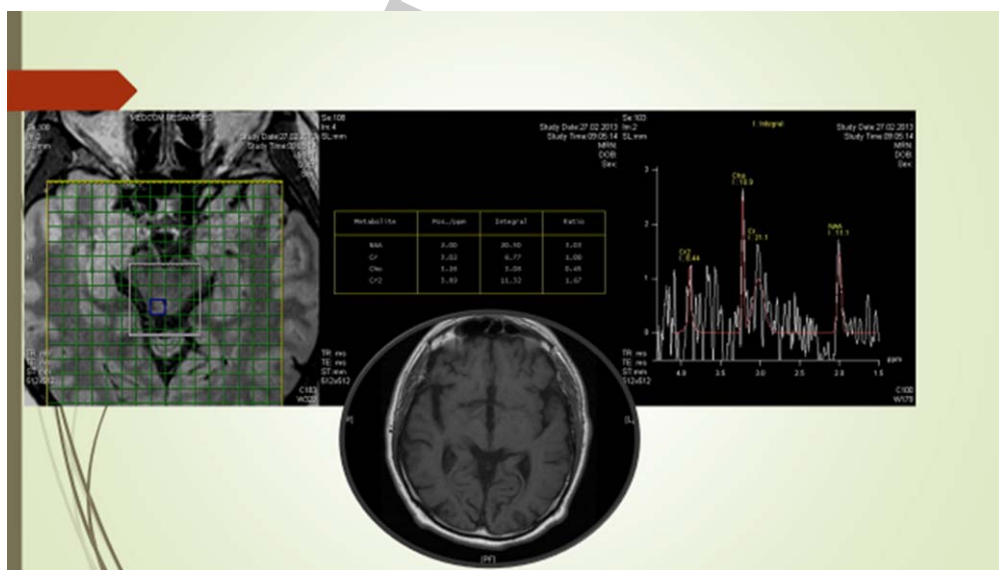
A normal MRI image from a mild cognitive impairment patient, and a ^1H -MRS image from the same patient showing abnormal biochemical changes.
